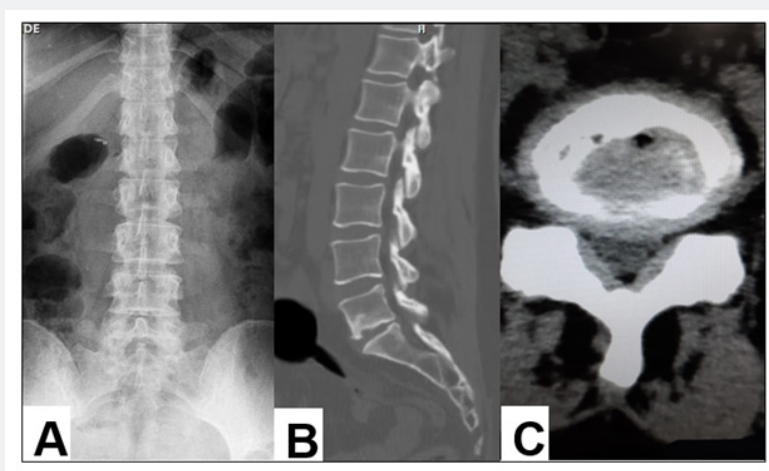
X-rays showing a supernumerary L6 vertebra (A) and CT scan showing slight degree of L6–S1 intervertebral disc degeneration (B and C).
